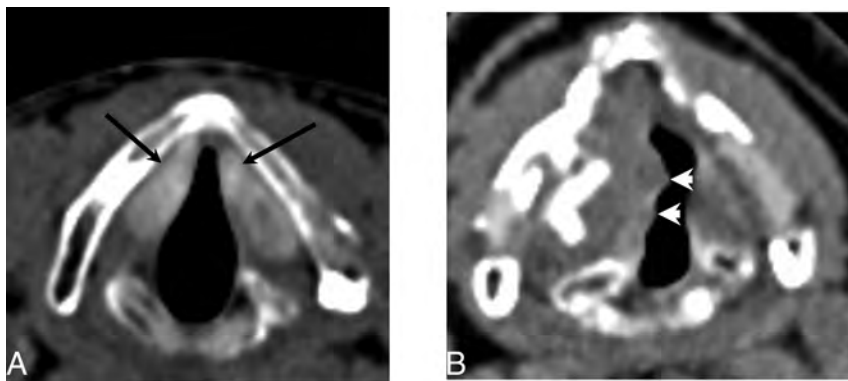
Teflon. A, Axial CT demonstrates hyperattenuating material in the bilateral vocal folds (arrows) consistent with Teflon injection. B, Axial CT in a different patient status post Teflon injection into the right vocal fold demonstrates a slightly nodular contour (arrowheads) consistent with granuloma formation, a common complication of Teflon.
